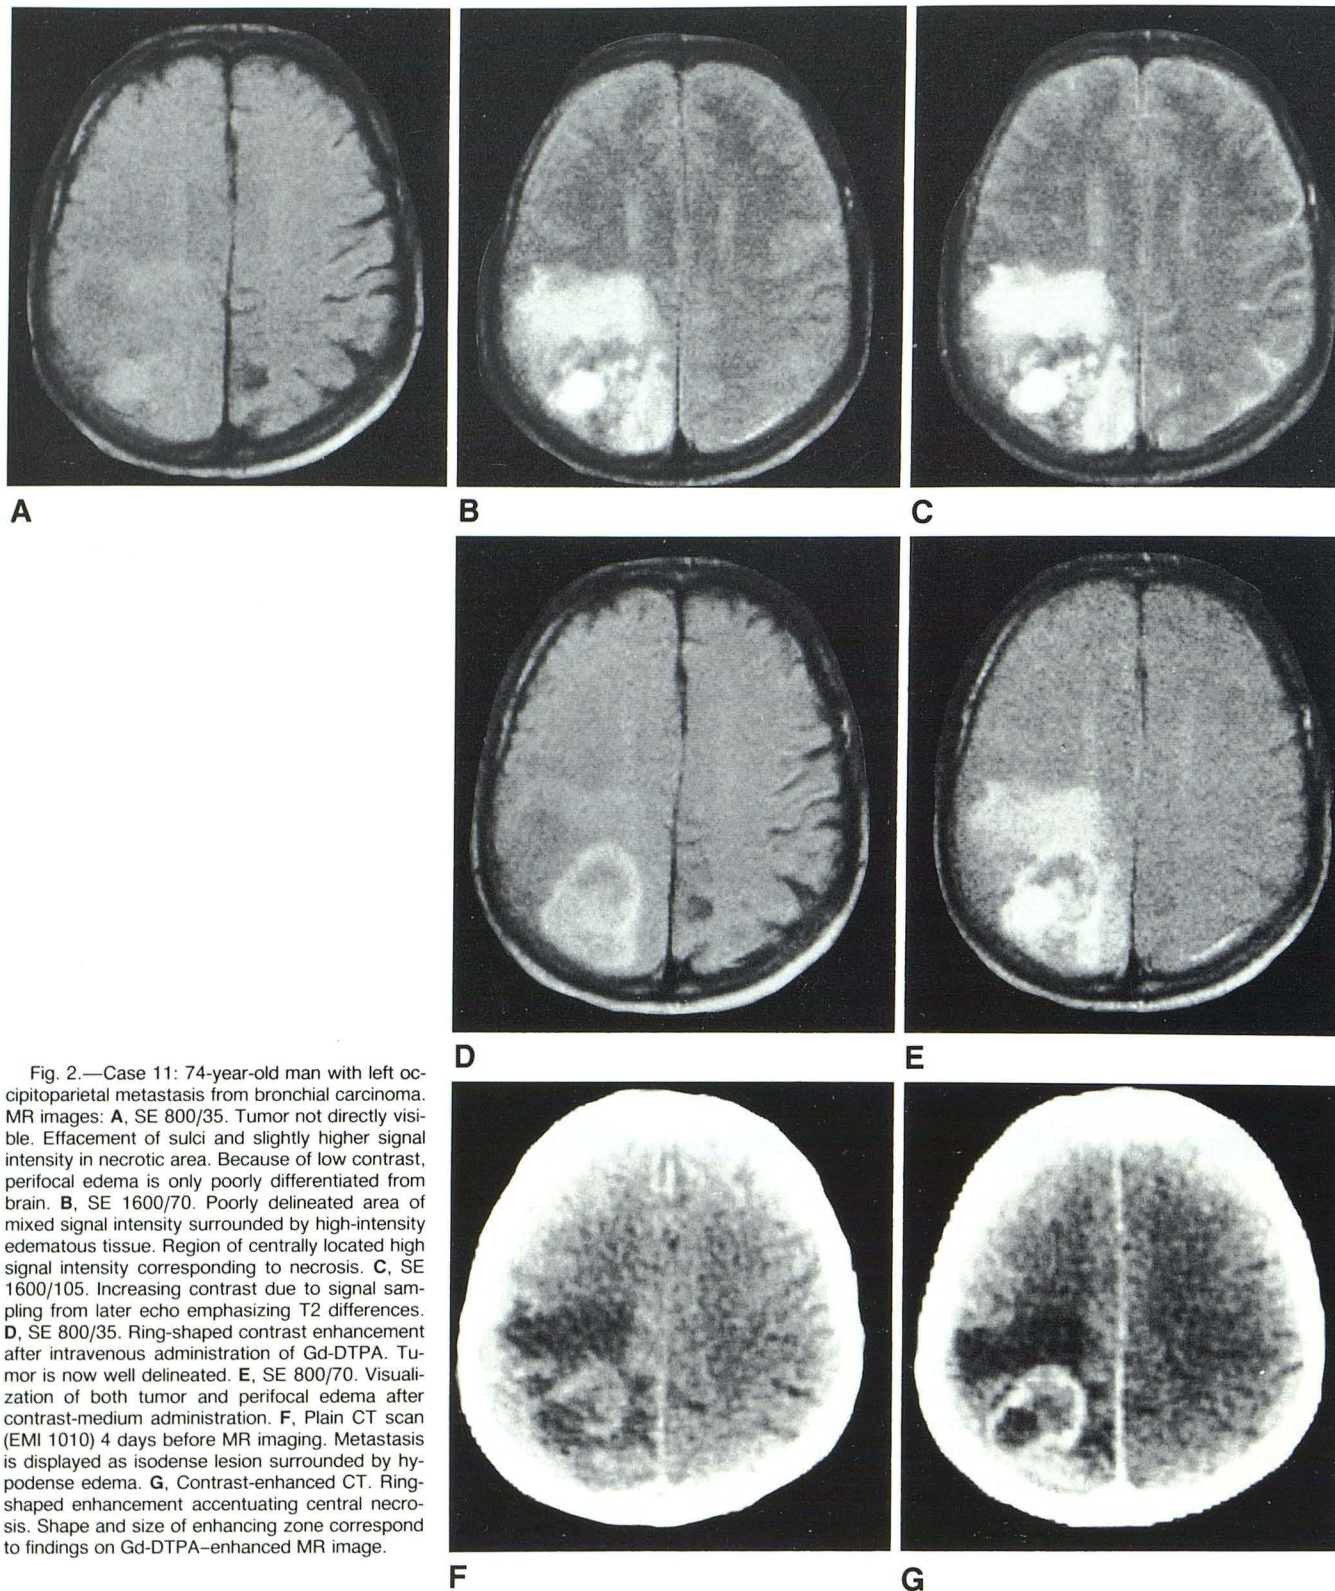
Case 11: 74-year-old man with left occipitoparietal metastasis from bronchial carcinoma. MR images: A, SE 800/35. Tumor not directly visible. Effacement of sulci and slightly higher signal intensity in necrotic area. Because of low contrast, perifocal edema is only poorly differentiated from brain. B, SE 1600/70. Poorly delineated area of mixed signal intensity surrounded by high-intensity edematous tissue. Region of centrally located high signal intensity corresponding to necrosis. C, SE 1600/105. Increasing contrast due to signal sampling from later echo emphasizing T2 differences. D, SE 800/35. Ring-shaped contrast enhancement after intravenous administration of Gd-DTPA. Tumor is now well delineated. E, SE 800/70. Visualization of both tumor and perifocal edema after contrast-medium administration. F, Plain CT scan (EMI 1010) 4 days before MR imaging. Metastasis is displayed as isodense lesion surrounded by hypodense edema. G, Contrast-enhanced CT. Ring-shaped enhancement accentuating central necrosis. Shape and size of enhancing zone correspond to findings on Gd-DTPA-enhanced MR image.
